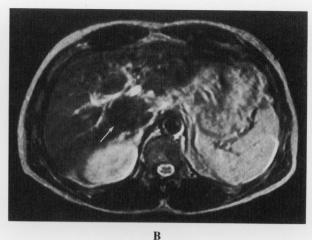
Non-neoplastic lesion in alcoholic hepatitis. A. GSA SPECT shows increased accumulation in the caudate lobe (arrows). B. The lesion exhibits hyperintensity on T1-weighted and hypointensity on T2-weighted MR image (white arrow).
